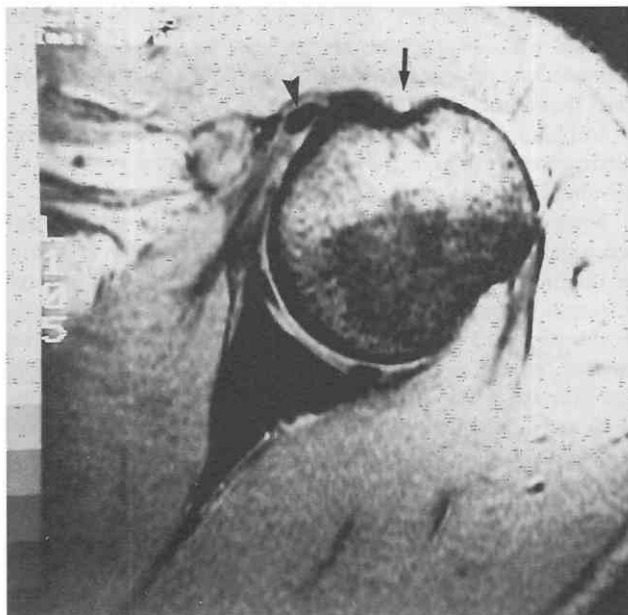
Bicipital tendon dislocation. Gradient-echo (TR = 600 msec, TE = 15 msec, flip angle = 70 degrees) axial MR image. The intertubercular groove is empty (arrow). The bicipital tendon is dislocated medially and lodged within the fibers of the subscapularis muscle and tendon (arrowhead).
